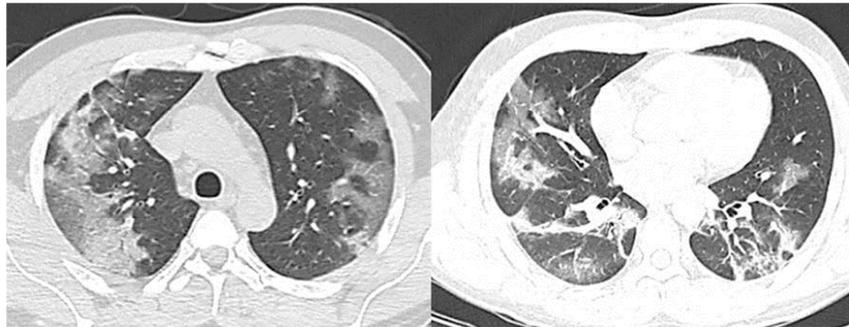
54-year-old male patient with COVID-19. The CT was performed on day 11 of COVID (phase 3), observing a combination of patterns, with the presence of ground glass opacities and consolidations.
